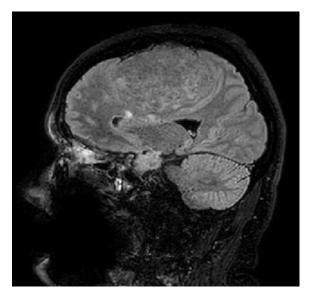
Sagittal FLAIR image. Extra axial, smoothly contoured, inhomogeneous signal intensity mass, located parasagittal to the left of the falx cerebri. Midline dislocation to the right. Left frontal, and parietal lobes are affected.
